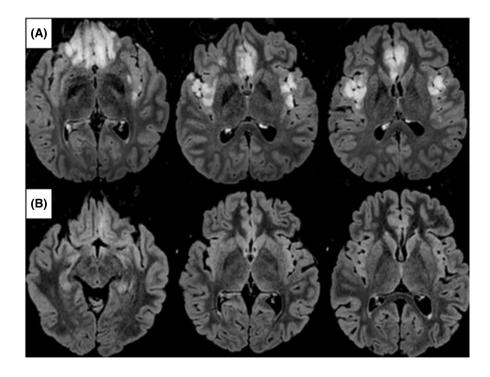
(A) Axial fluid-attenuated inversion recovery (FLAIR) on day 12 of hospital admission. Magnetic resonance imaging (MRI) shows symmetrical cortical high FLAIR signal in both frontal lobes, cingulate gyri, and insular cortices. (B) Axial FLAIR at 3 months of followup. MRI shows complete resolution of the previously described cortical high FLAIR signals, except for some residual hyperintensity in the left gyrus rectus
